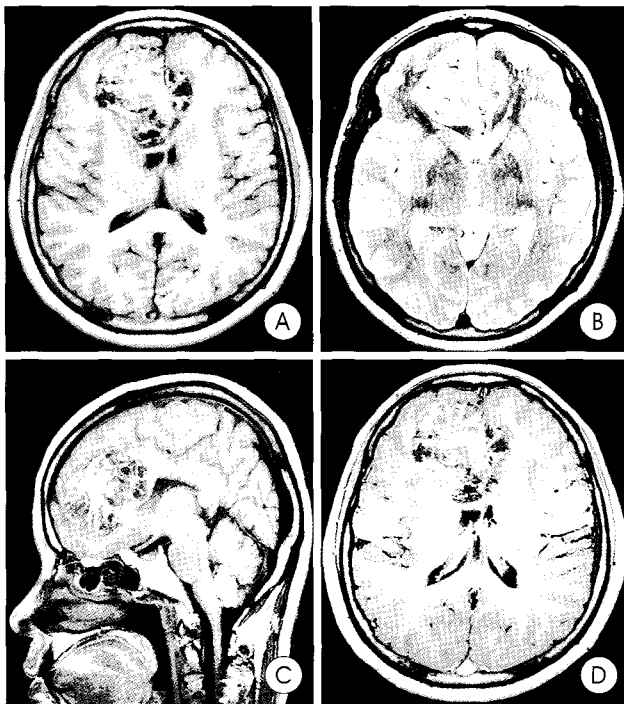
Axial T1-weighted (A), T2-weighted (B), and sagittal T1-weighted (C) magnetic resonance images demonstrating a mass lesion of heterogeneous signal intensity in the interhemispheric fissure and faint enhancement with gadolinium (D).
